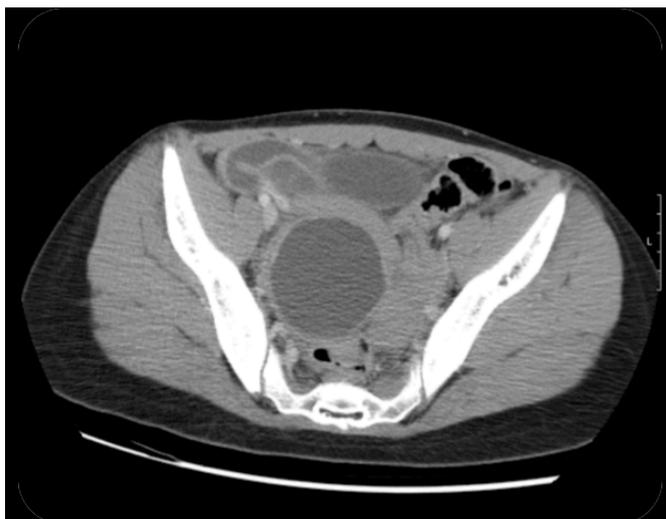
Pelvic computed tomography (axial plane) with cystic formation, with slightly thick walls, suggestive of cystic lesion of ovarian origin
